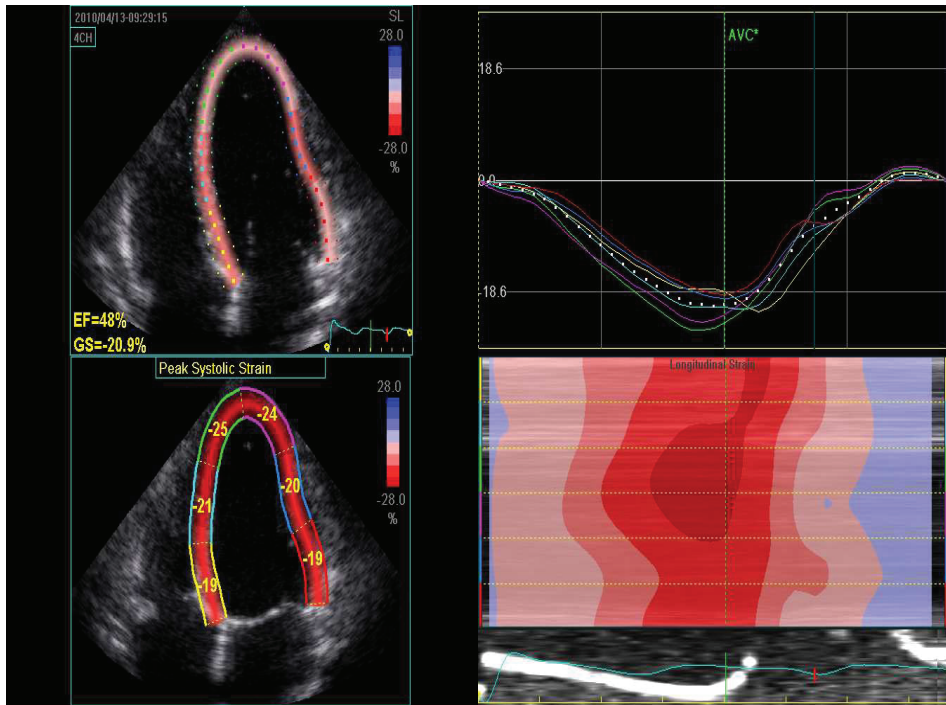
Speckle tracking longitudinal strain curves from 6 segments in apical 2 chamber view from a healthy pregnant individual.
